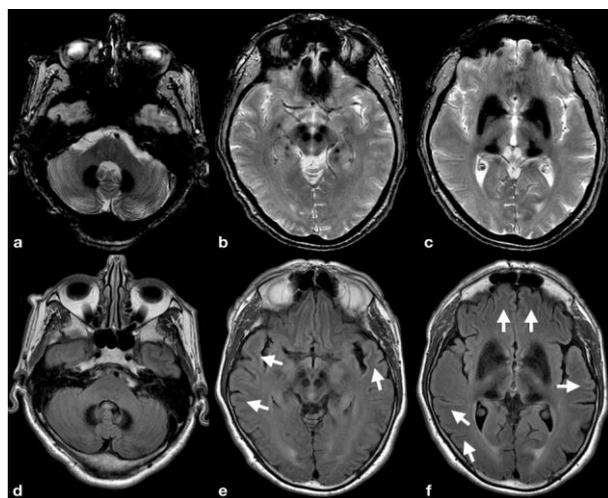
T2-weighted GRE (top row) and FLAIR (bottom row) sequences passing through the middle cerebellar peduncles (a, d), midbrain/diencephalon (b, e) and the basal ganglia region (c, f). Iron deposits are appreciable as "blooming" hypointensity areas bilaterally in the dentate nucleus (a,d), red nucleus and substantia nigra (b, e), basal ganglia and thalami (c, f). Subcortical white matter ("U" fibers) involvement is well demonstrated in FLAIR imaging (arrow in e and f).
